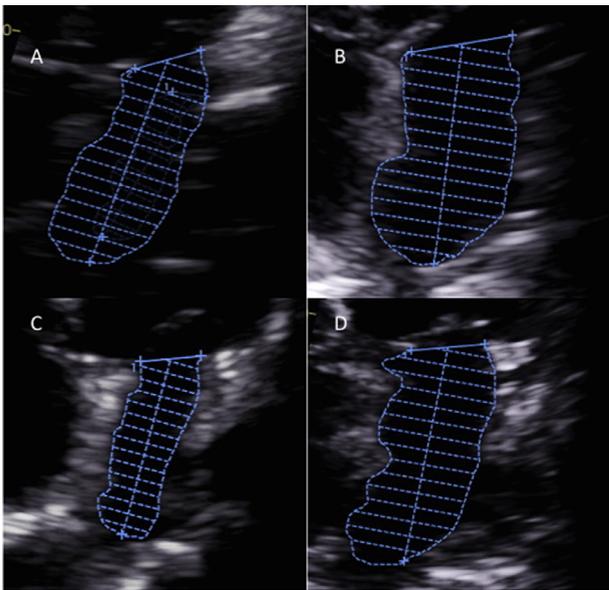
The 2D echocardiogram with the outline of LA end-diastolic cavity in the 4-chamber view traced to compute volume by the biplane method of discs. In this example, the 2-chamber orthogonal plane used in the computation is not shown. Panel (A) shows a normal subject at rest compared to ESUS subject in panel (B). Panels (C) and (D) compare the normal versus ESUS LA volumes during exercise, respectively.
